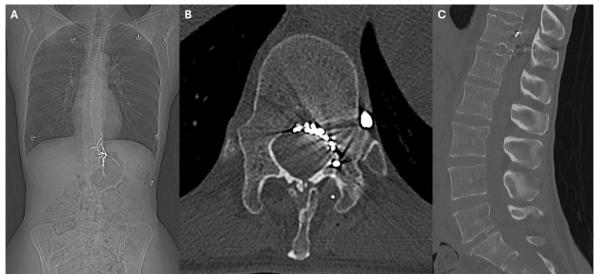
66-year-old female with a left T12 CVF. Scout image (A) from a post-embolization CT of the thoracic and lumbar spine, (B) axial CT at the level of the embolization shows Onyx in the internal vertebral venous plexus and a paraspinal vein, and (C) sagittal CT of the lumbar spine do not show Onyx in the subarachnoid space.
